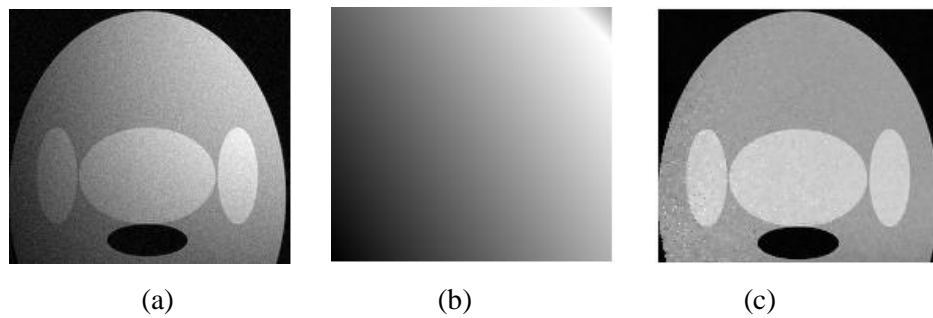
(a) Synthetic MRI slice (b) estimated bias field for Fig. 6.3(a) (c) IIH reduced slice.
